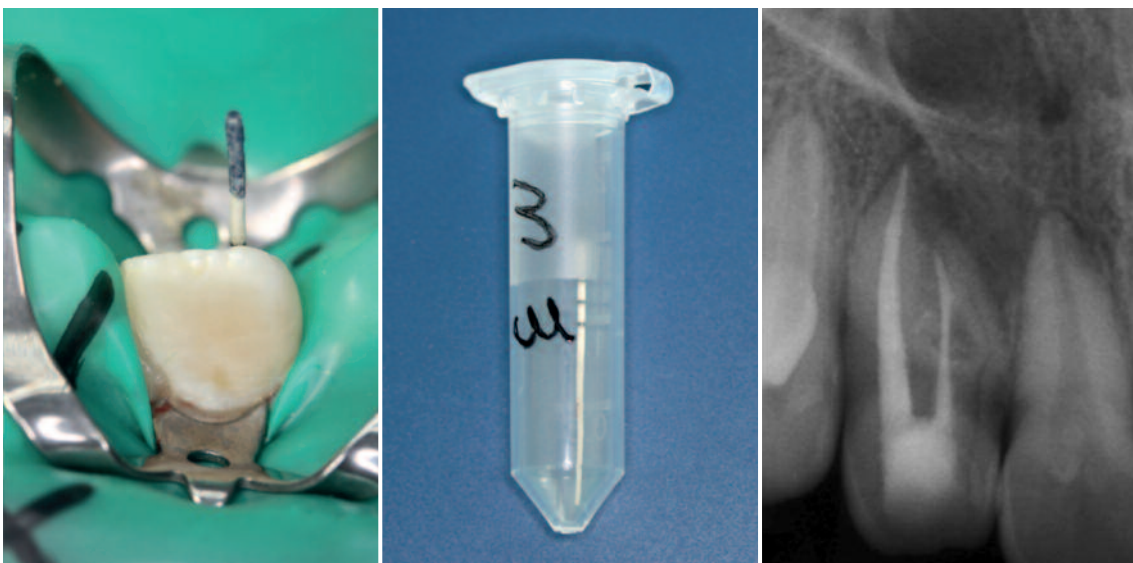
Microbiological sampling after laser irradiation of the inner canal walls with a sterile paper point. – Fig. 11: Paper point prepared for transporting for real-time PCR analysis after removal from the treated root canal system. – Fig. 12: Follow-up X-ray image after root canal filling. Compared to the original image, a tendential decrease in the apical change is noticeable.
